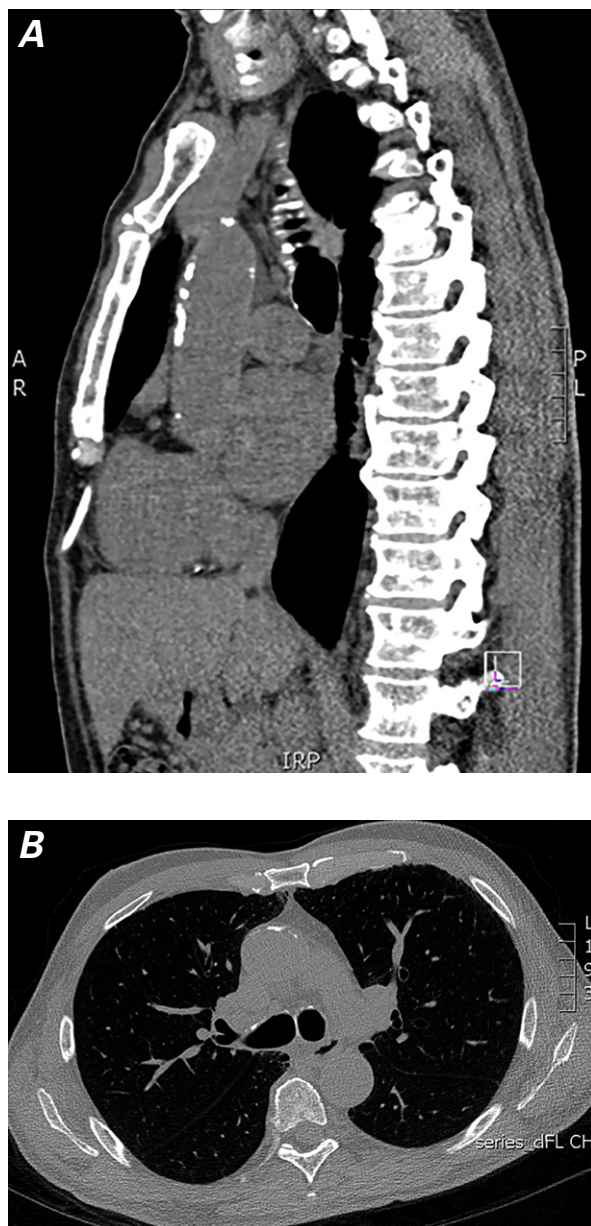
Noncontrast computed tomograms of the chest and upper abdomen in A) sagittal and B) cross-sectional views show calcification of the anterior wall of the ascending aorta.
